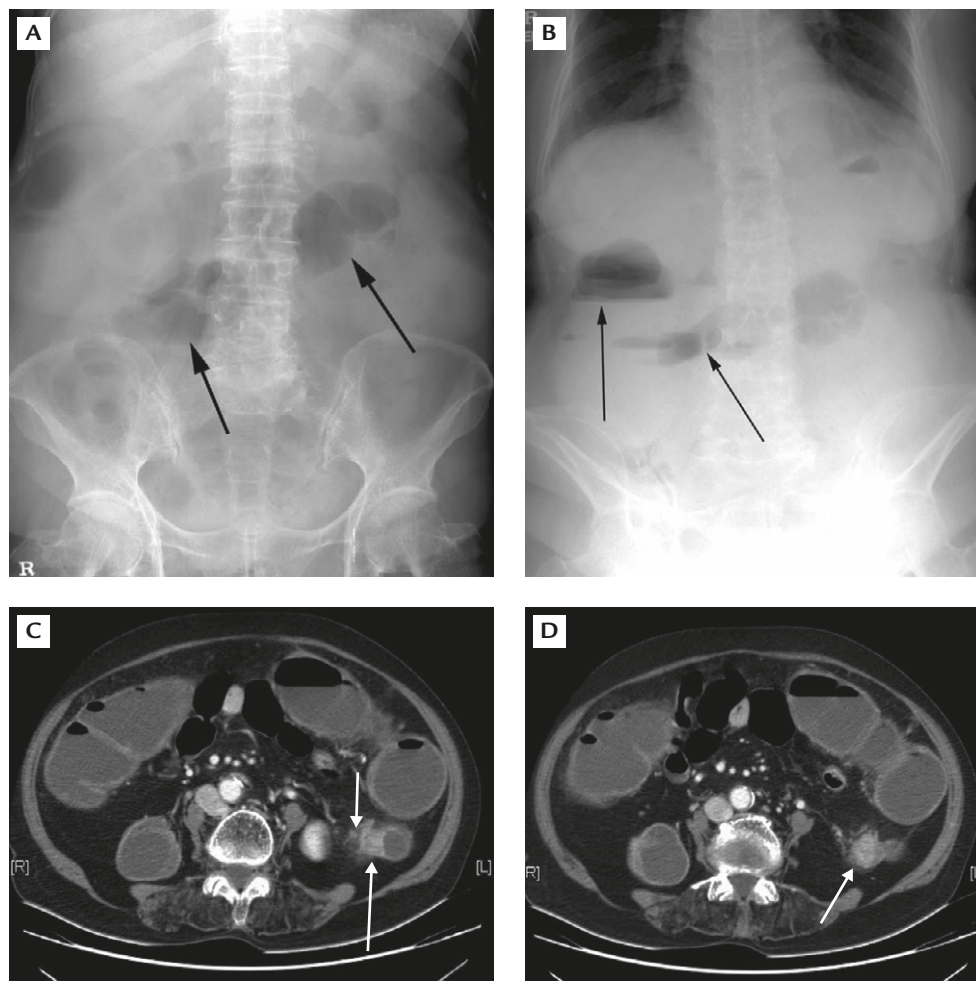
Simple abdominal X-ray, flat (A) and upright (B) view of descending colon cancer patient. Focal gas distension in small bowel and air-fluid level suggest intestinal obstruction (black arrows). Abdominal pelvic CT of descending colon cancer patient. Pericolic fat infiltration and regional lymph nodes are noted (C). There is a short segment stricture with a bulging mass in the descending colon (D). The proximal colon and terminal ileum are dilated.
